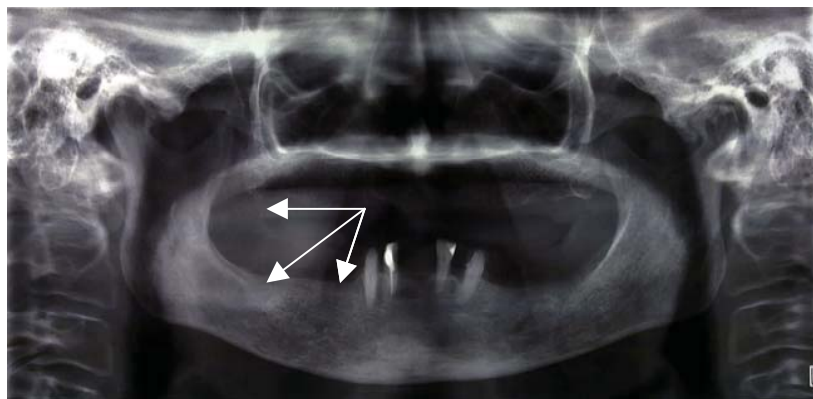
The orthopantomographic radiography, 2 years after second surgery, showing a complete and successful bone healing on the right side of the mandible (arrows).
